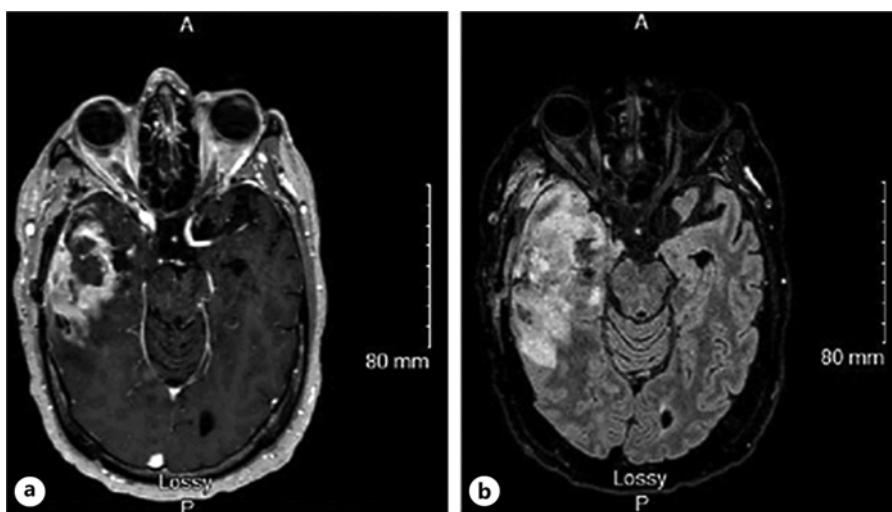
Axial magnetic resonance imaging (T1 with contrast (a), T2 FLAIR (b)) revealing new focus of increase tumor margin enhancement and an increase in lesion size, concerning for progressive disease.
